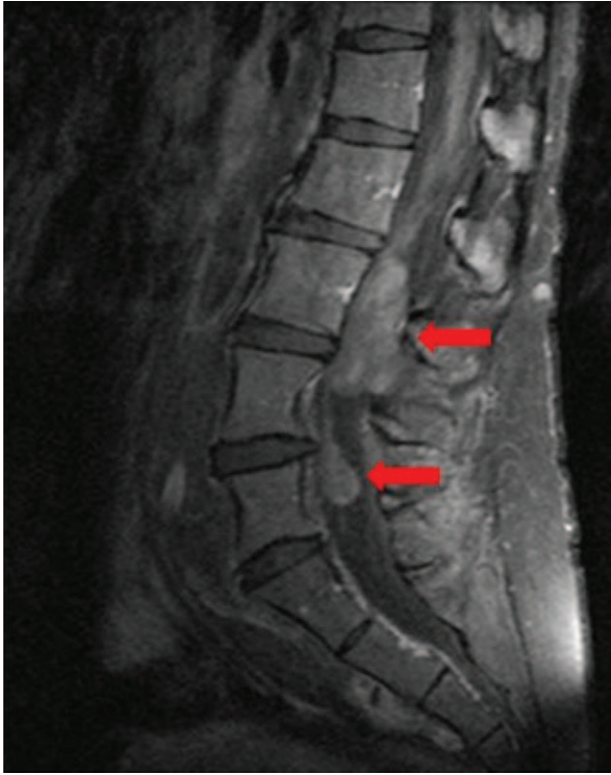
Sagittal T1-weighted contrast spinal magnetic resonance image showing 2 heterogeneously enhancing intradural masses at the L3, L4, and L5 levels. The upper one measures about 46 × 19mm, and the lower one measures about 18 × 12mm. These 2 masses were diagnosed as neurofibroma through biopsy. They were removed by surgery.
